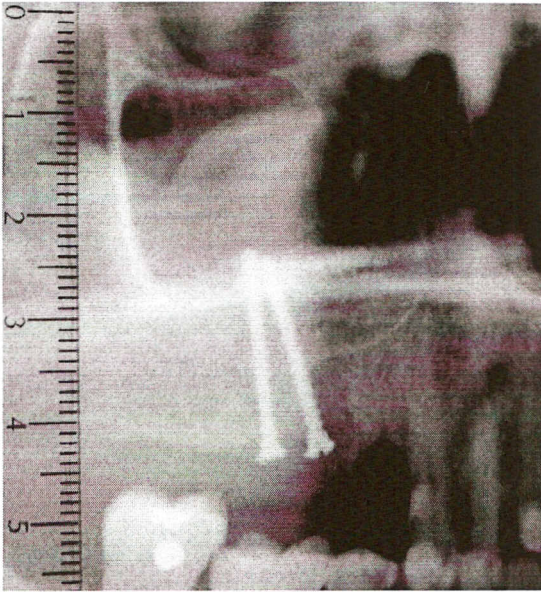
Orthopantomograph showing the graft inserted in the uppers right maxilla and fixed with screws.
